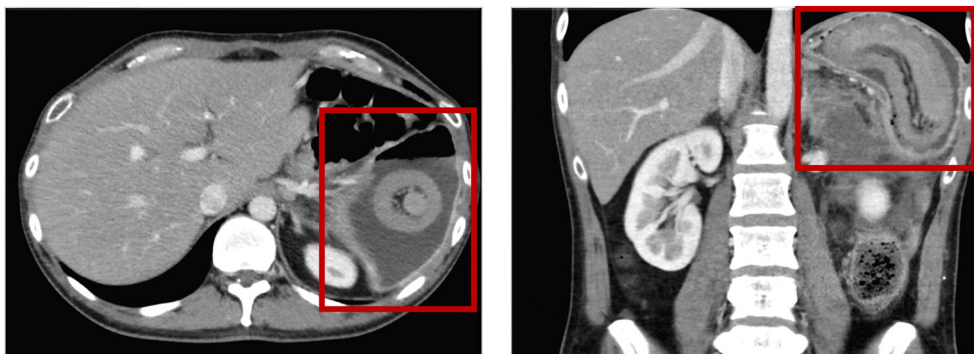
CT imaging demonstrating jejuno gastric intussusception.
